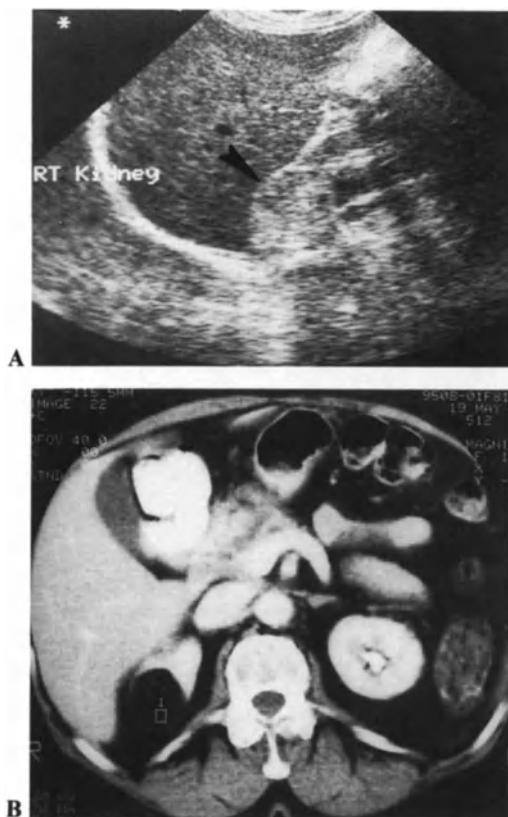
Angiomyolipoma. A Ultrasound scan, sagittal section, right kidney, shows echogenic mass in the upper pole (arrowhead). B CT scan, with contrast, shows the lesion containing tissue similar to retroperitoneal fat. The cursor measured an attenuation coefficient of  $-70 \text{ HU}$ .
